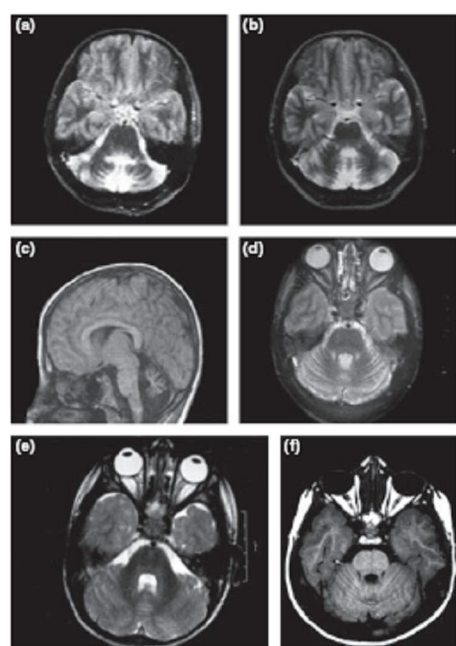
Brain structural MRI in six ataxia-telangiectasia (A-T) patients. (a, b) T2 sequence on axial sections showing marked cerebellar atrophy in P1 and P2. (c) T1-weighted sagittal section showing moderate cerebellar and vermal atrophy. (d) T2 sequence on axial sections showing moderate cerebellar and vermal atrophy. (e, f) Normal cerebellum in P5 and P6.
